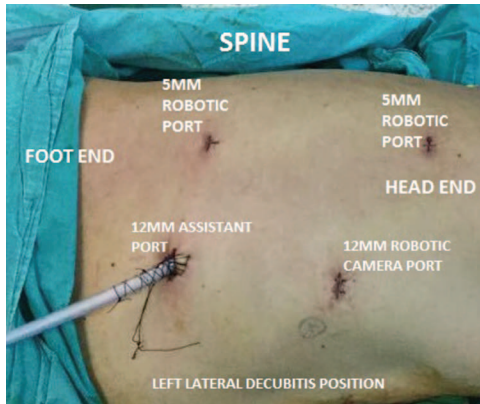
Operative position and ports for robotic transthoracic esophageal diverticulectomy.
